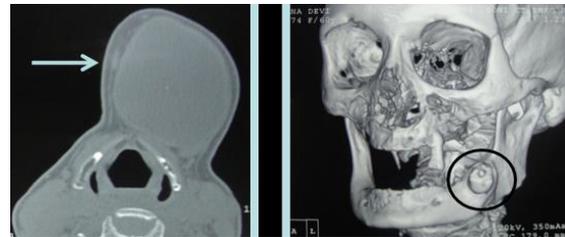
CT scan reveals well defined heterogeneous attenuated soft tissue density in left mandibular alveolar region with erosion of underlying mandibular ramus, and cortical breach out.
